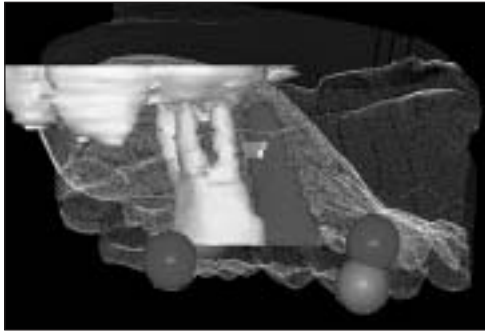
The 3D integrated image of CT and dental cast with the 5 ceramic marker balls.
